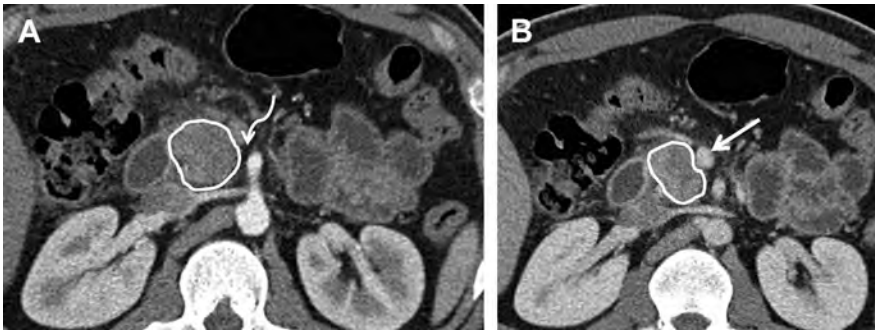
In a 35-year-old man with abdominal pain, CT scan in the pancreatic parenchymal phase (A) and portal venous phase (B) shows a 3-cm pancreatic head/uncinate mass (outlined) abutting ($<180^\circ$) the SMV (straight arrow) with no involvement of the superior mesenteric artery, as shown by the preserved fat plane (curved arrow). There were no metastasis, and this case was resectable.
